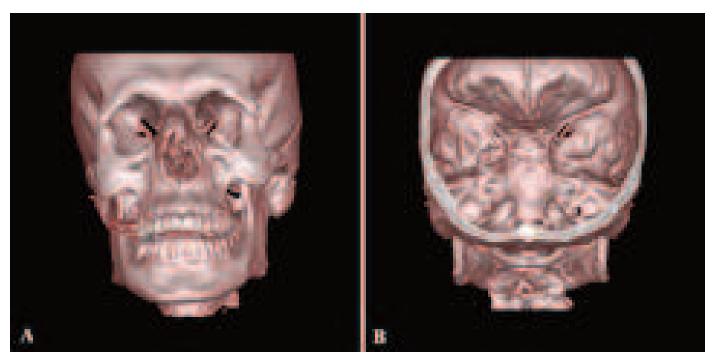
Preoperative 3D CT scans of the skull. (A) An anterior view demonstrates the obliterated superior orbital fissure (arrow) as a result of a complex fractures displacing the lateral orbital wall medially and (B) posterior view of the obliterated superior orbital fissure (arrow). 3D CT=three-dimensional computed tomography.
